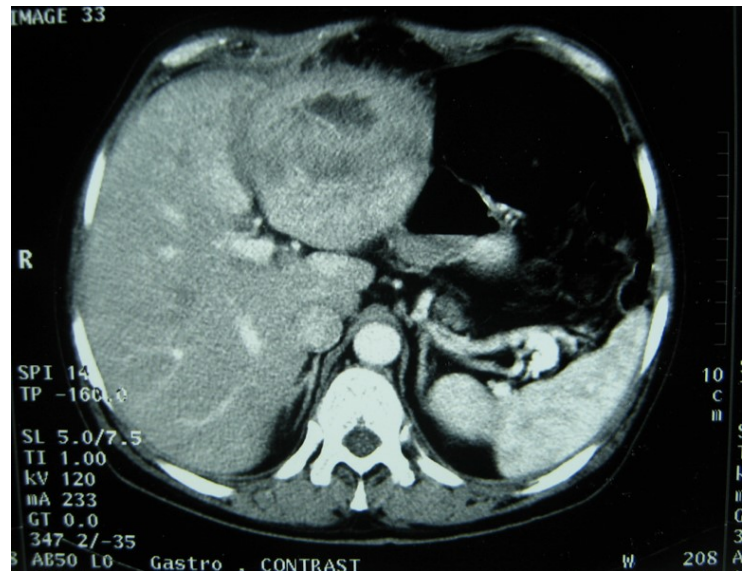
Abdominal computed tomography with intravenous contrast showing the lesion with ring enhancement.
